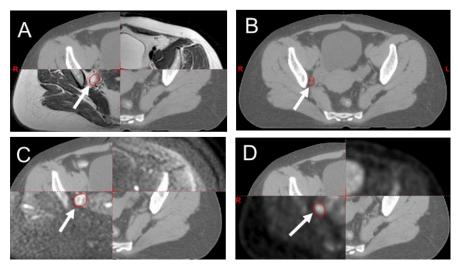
Role of co-registered modalities in selection and delineation of GTV N. (A) T2W FSE MRI is the primary modality for selection and delineation: a pathological lymph node (<10 mm but with pathological morphology) is contoured. (B) CT has limited role in selection and delineation of GTV N. (C) DWI confirms the selection of the lymph node which shows restricted diffusion, but it doesn't show soft tissue details and is therefore of limited value for delineation. (D) 18-FDG PET additionally confirms the selection of the lymph node, but it is also of limited value for detailed delineation due to limited soft-tissue depiction. (A-D) Information from all modalities is considered when contouring on primary modality (MRI).
